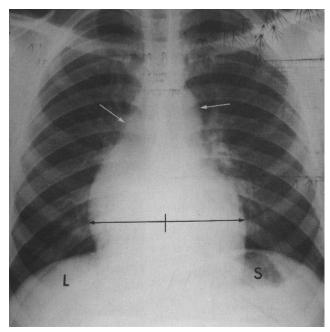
X-ray from a 16-year-old male patient in situs solitus with a midline heart and no congenital heart disease. The cardiac silhouette extends equally to the right and left (black arrows). The stomach (S) is on the left, and the liver (L) is on the right. The ascending aorta and aortic knuckle (unmarked white arrows) are normally positioned. The humpshaped appearance of the lower right silhouette is due to superimposition of the right atrium and right ventricle. Reproduced with permission from Perloff JK. The Clinical Recognition of Congenital Heart Disease. 5th ed. Philadelphia, Pennsylvania: W.B. Saunders, 2003.
